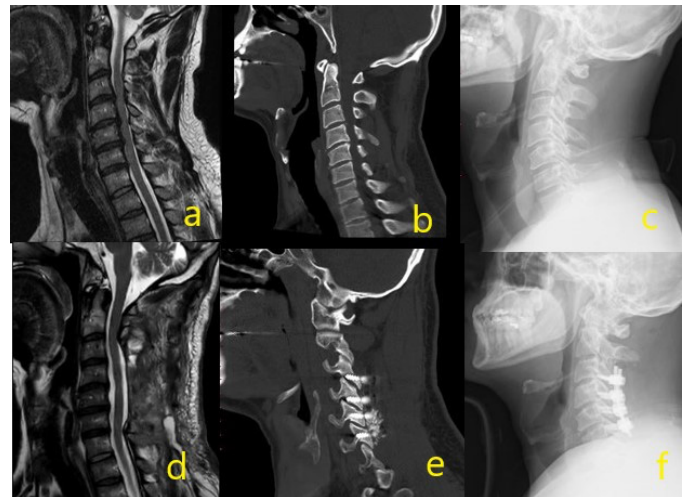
Radiological images of the 58-year-old male patient with CSM who underwent total laminectomy with decompression + lateral mass fixation between C3-6 are shown above. Preoperative magnetic resonance, computed tomography, and lateral X-ray images are demonstrated between a-c). In d-f) images, postoperative images are displayed on MRI, CT and direct lateral radiography, respectively.
